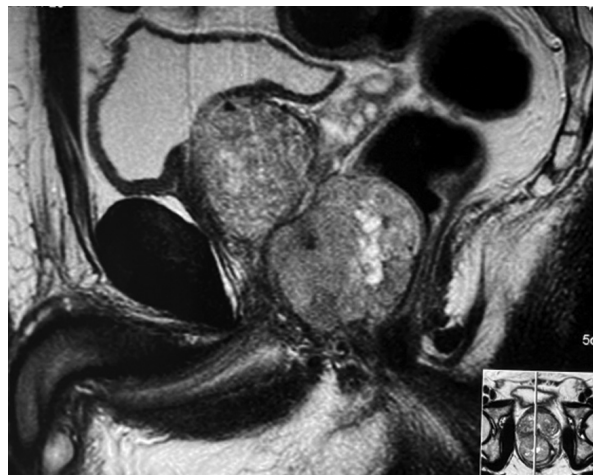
Magnetic resonance imaging of a rectal gastrointestinal stromal tumor that allows us to appreciate its anatomical relationships in the pelvis.
